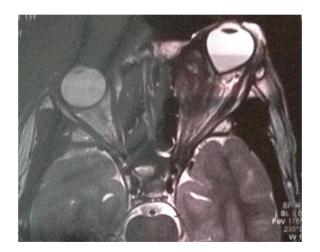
MRI on the seventh hospital day, first postoperative day after left orbital exploration and decompression with tumor debulking. A large peripherally enhancing mass primarily located along the extraconal compartment of the left orbital cavity causing marked proptosis of the left globe.
